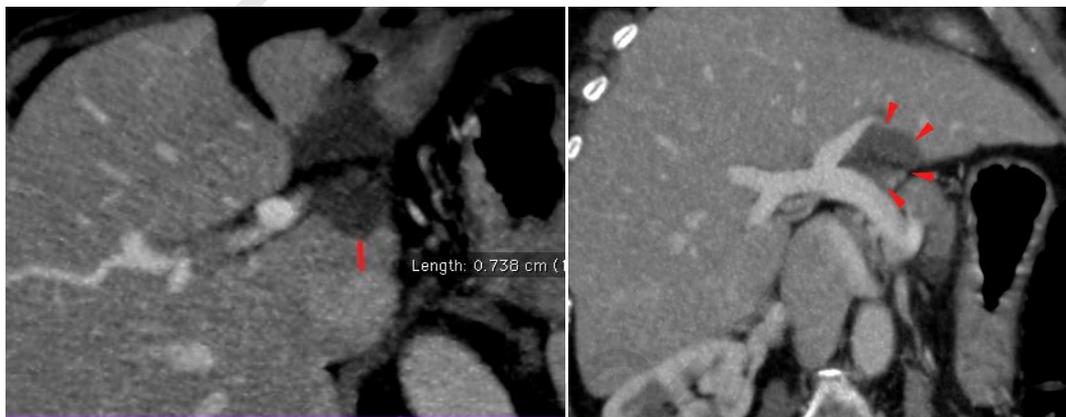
(A) axial MDCT study ; venous phase of triphasic CT study showing a hypodense lesion in segment III /caudate lobe interface.
